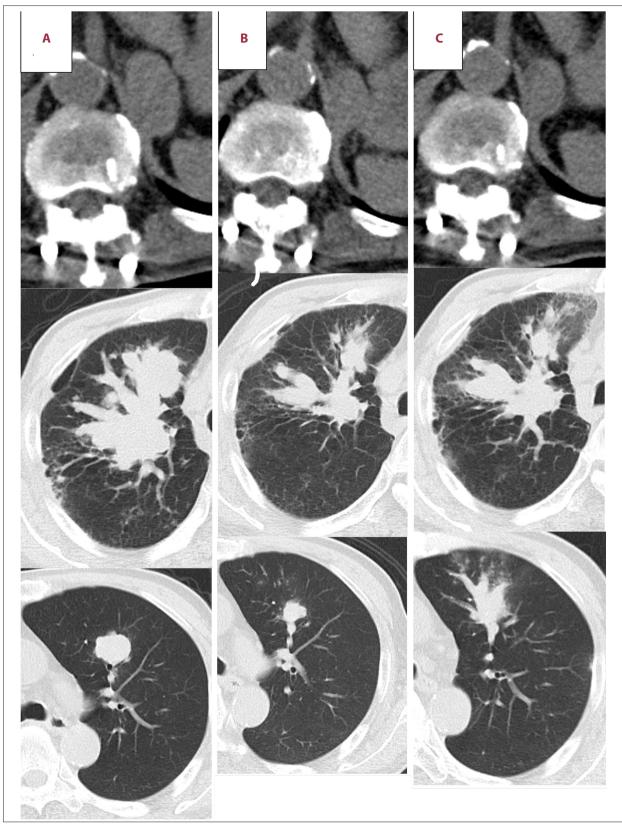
The CT scan shows left adrenal and lung metastases before re-challenge with nivolumab (A), PR after 5 cycles of readministration (B), and enlarged after 7 cycles of re-administration (C).
